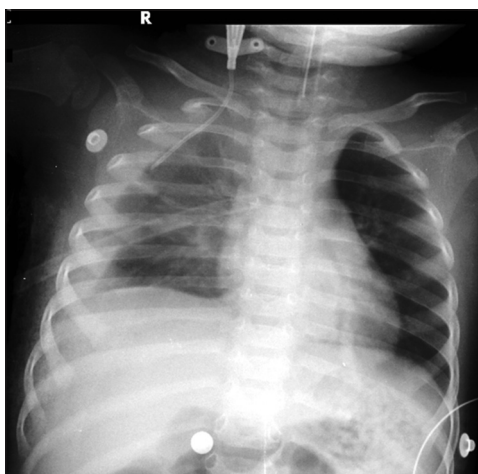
Chest X-ray showing malpositioned catheter with hemothorax
